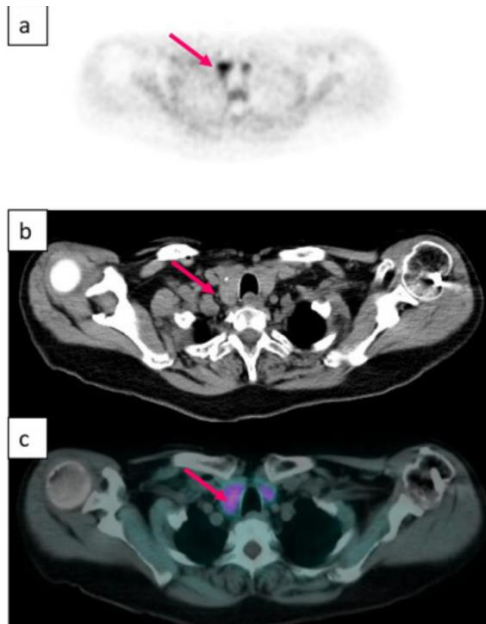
RIGHT INFERIOR PARATHYROID ADENOMA DETECTED BY 18F-CHOLINE PET/CT. ADAPTED FROM (9).
